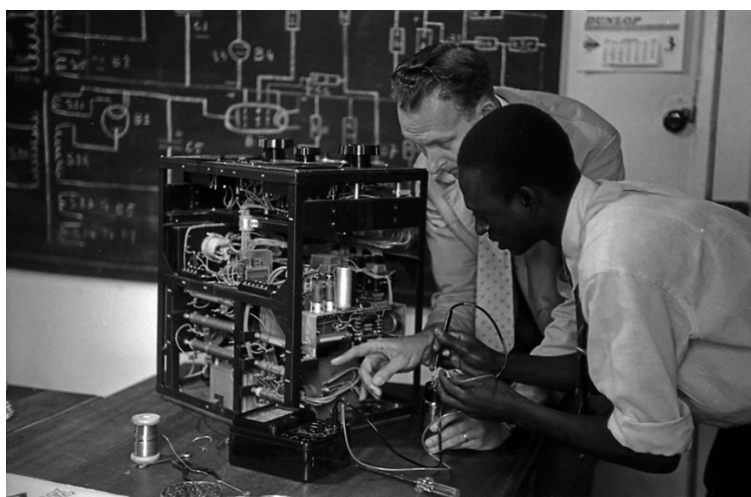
“At the TB Chemotherapy Centre Laboratory in Nairobi, Kenya, trainees learn to repair X-ray equipment under the supervision of WHO X-ray technician Mr van Hoegaerden (Belgium).” 1964, HQ31049, WHO Photo Library.
